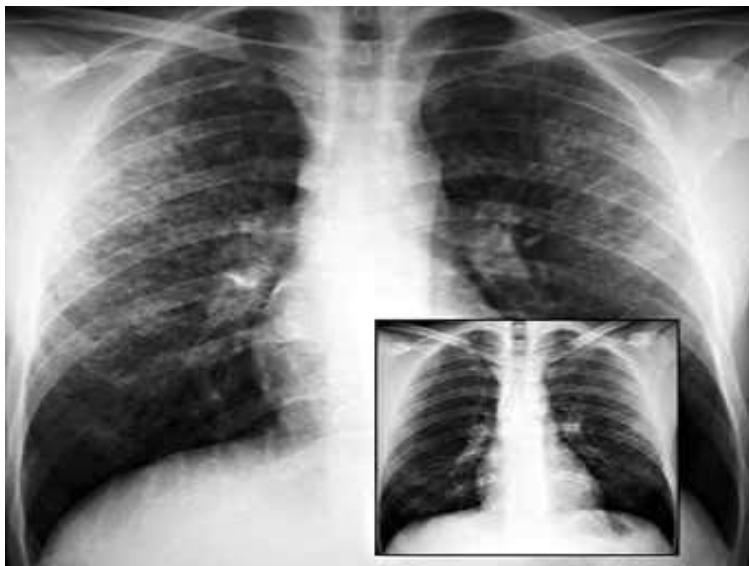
Radiograph: Pulmonary infiltration (without perihilar lymphadenopathy).
